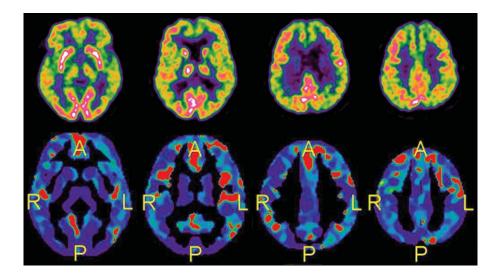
Example of absence of AD hypometabolic pattern according to the expert but with a positive PALZ score (T-sum = 15,180) in a 79 year-old woman with persistent aMCI after a 42-month follow-up. On top, FDG-PET visual analysis does not clearly show reduced uptake in the typical AD regions. On bottom, statistical PMOD maps shows significant hypometabolic clusters sparsely distributed in bilateral frontal and temporal lobes, the anterior cingulate cortex, right cuneus and posterior cingulate cortex, and left parietal lobe. Other details as in Fig. 1.
